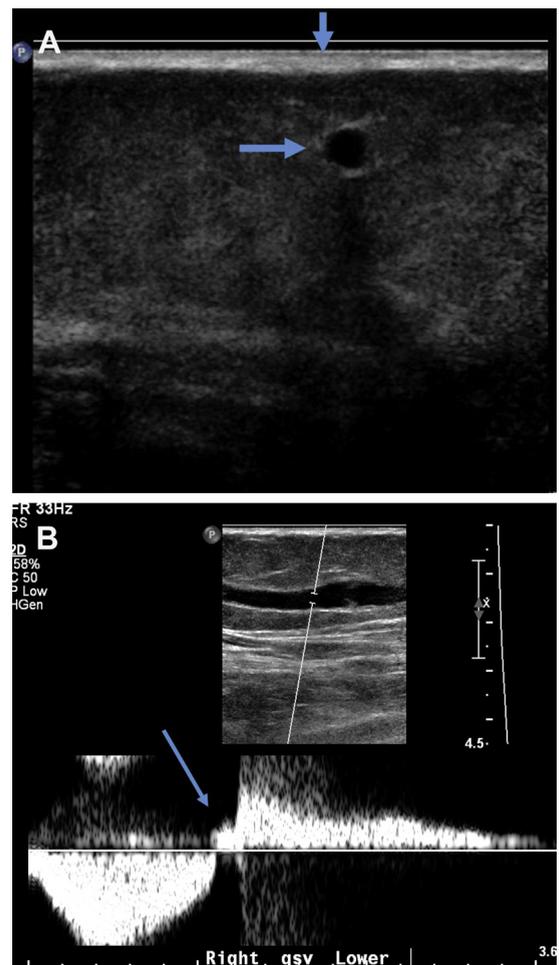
(A): Gray scale ultrasound of the lower extremity showing the dilated abnormal varicose vein (horizontal arrow) that is just below the skin surface (vertical arrow). (B): Spectral Doppler ultrasound of the abnormal vein demonstrating reflux on Valsalva maneuver (arrow) as change of the direction of flow.
